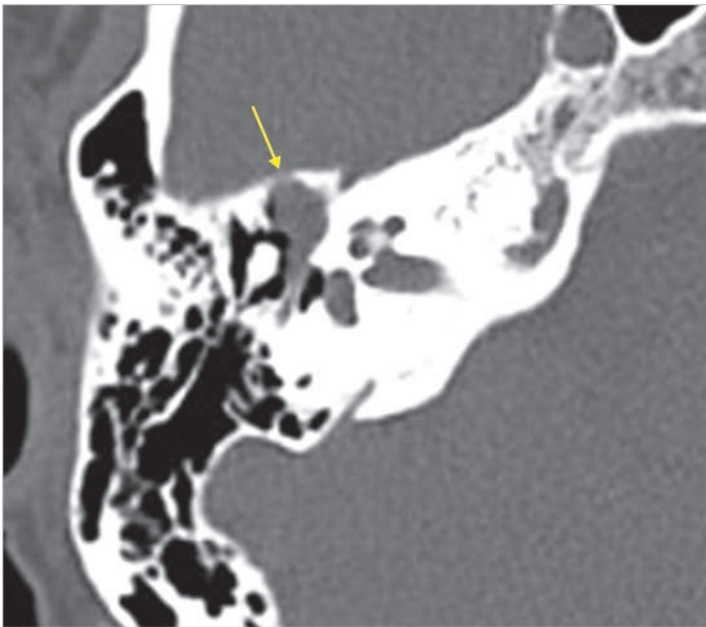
CT scan of the same case, axial view. The cholesteatoma involves the supratubal recess (arrow). The mastoid is free from the disease.
